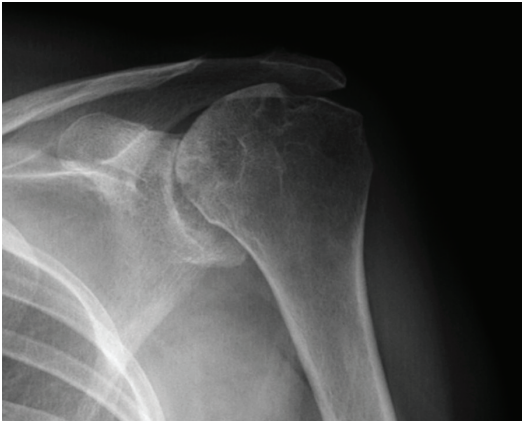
Antero-posterior radiograph of a 42-year-old patient showing Hamada 4B left glenohumeral osteoarthritis.
